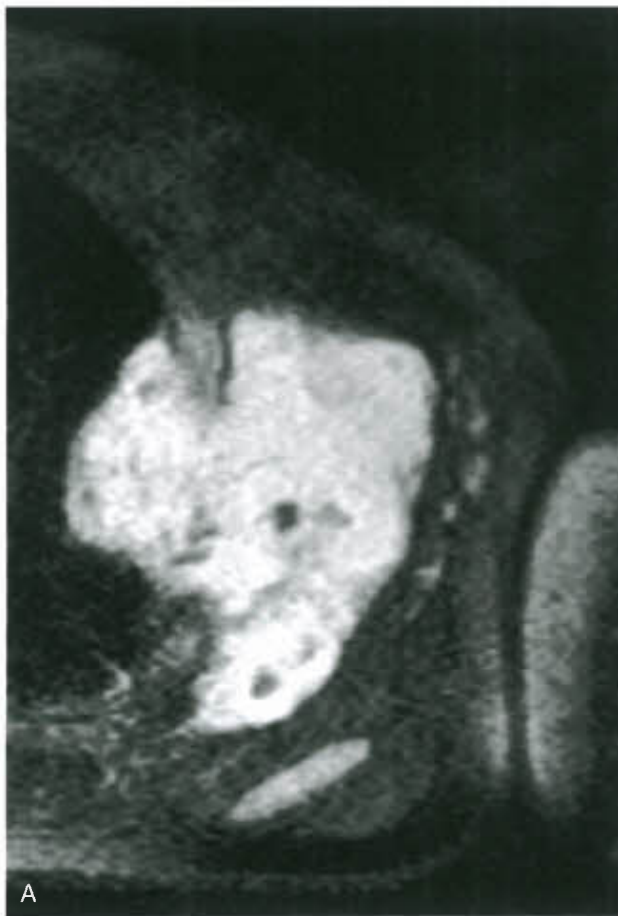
MRI of venous malformation. A: Axial T2 sequence showing the hyperintense signal of the VMs of the chest wall with herniation into the thoracic cavity. The signal reflects the dominant fluid (blood) component. Note multiple hypointense foci representing phleboliths. B: Partial, heterogeneous enhancement on axial T1 sequence following contrast administration.
